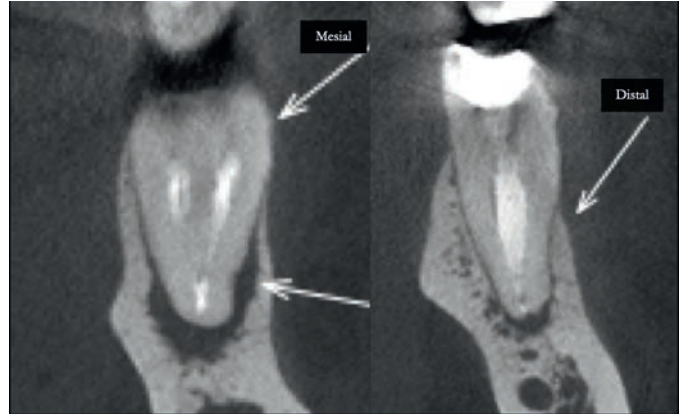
CBCT coronal images.
